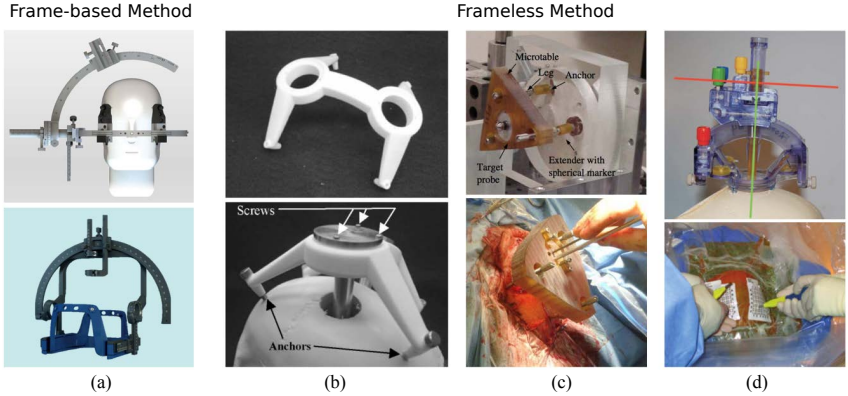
Electrode placement systems utilized in DBS surgery : frame-based and frameless method. (a) ZD-stereotactic system from inomed (Emmendingen, Germany) and Leksell Vantage from Elekta (Stockholm, Sweden). (b,c) A customizable frame STarFix microTargeting platform and Microtable developed at Vanderbilt University [18], [19]. (d) ClearPoint system with the skull-mounted aiming device SmartFrame for interventional MRI-guided DBS from MRI Interventions Inc (Irvine, CA, USA).
